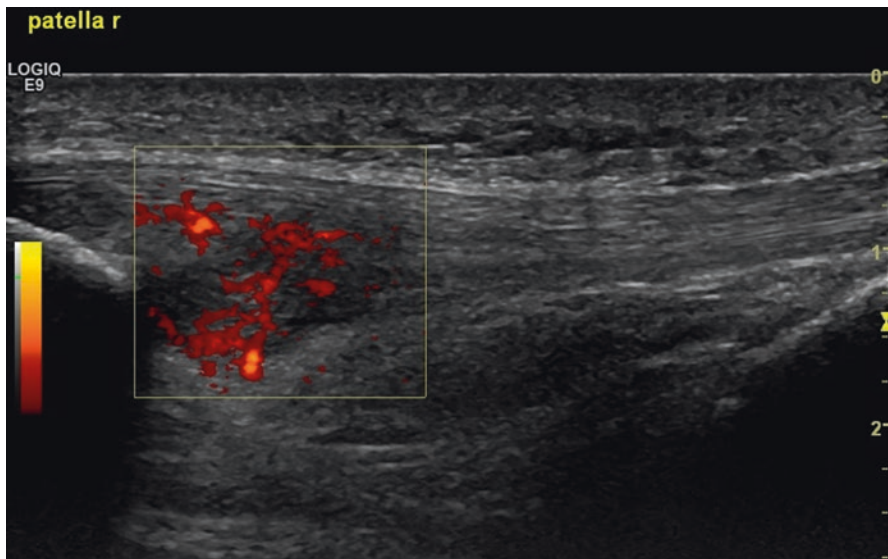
Longitudinal ultrasound image of the patella tendon (proximal on the left, distal to the right)
